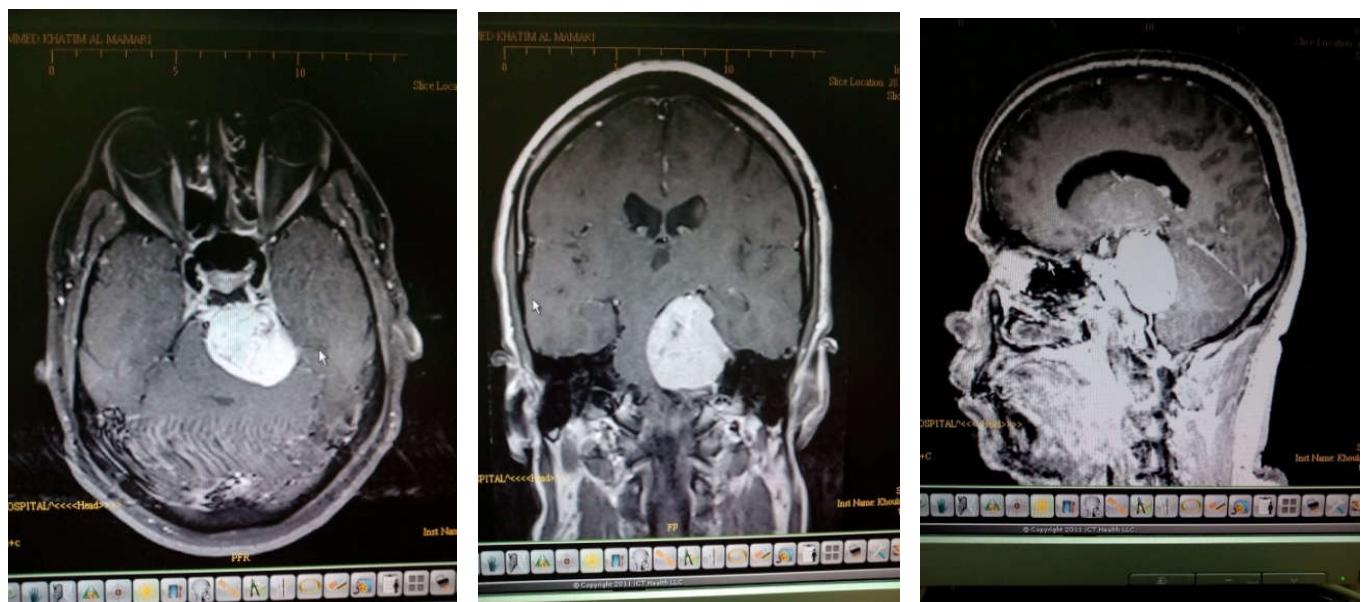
Pre operative MRI
